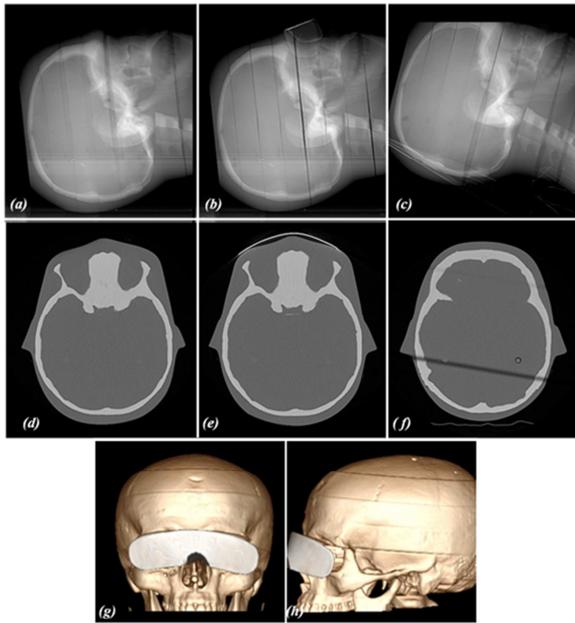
CT head images: without eye shielding (a, d), with eye bismuth shielding (b, e) and head tilted (c, f). The 3D reconstruction image with bismuth shielding: frontal (g) and lateral (h).
